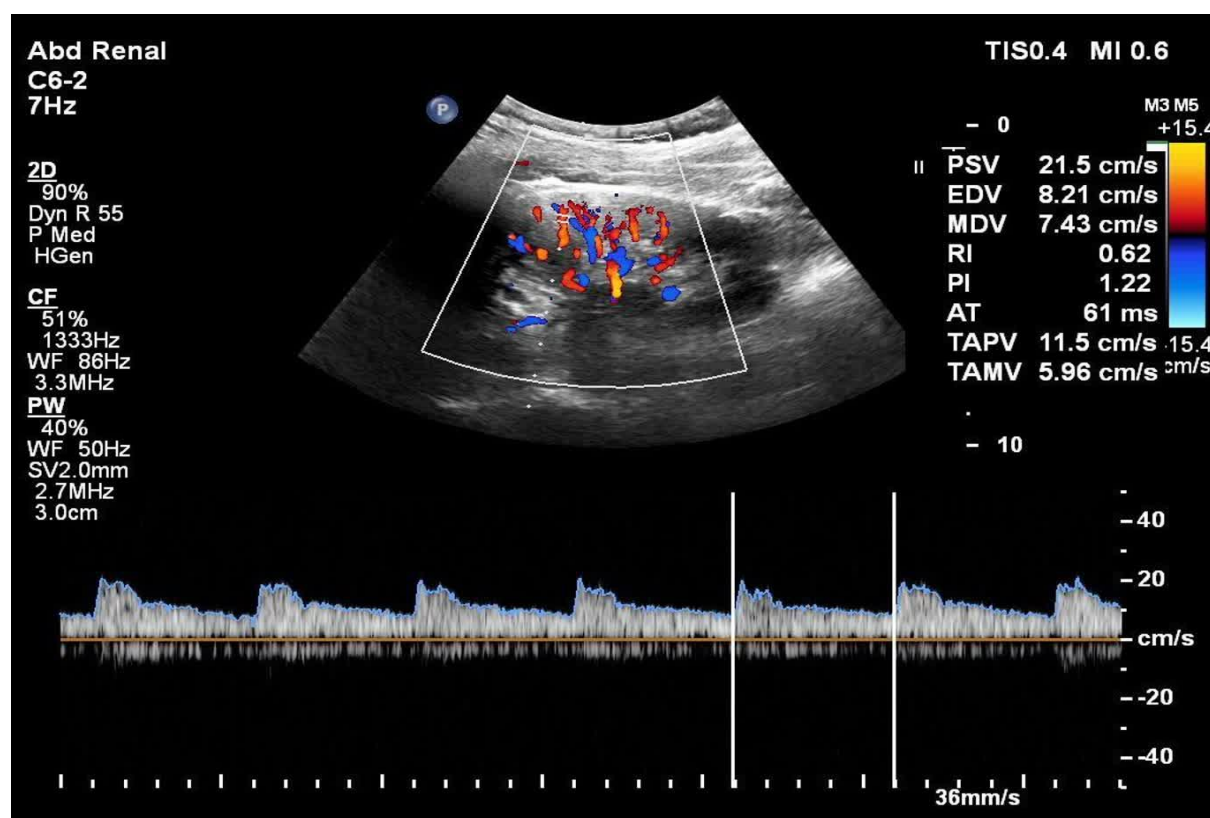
Renal Color Doppler ultrasound
